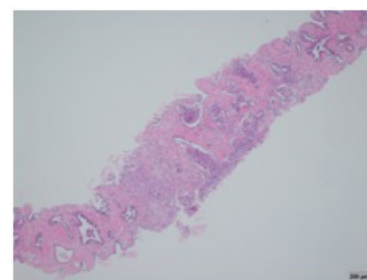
MRI T2WI, DWI, and pathological slides (H.E.) of (a) granulomatous prostatitis with PI-RADS score 5, (b) prostate cancer with PI-RADS score 5, and (c) urothelial carcinoma with PI-RADS score 4. Note the differences in pathological findings despite the similarity in imaging appearances.
